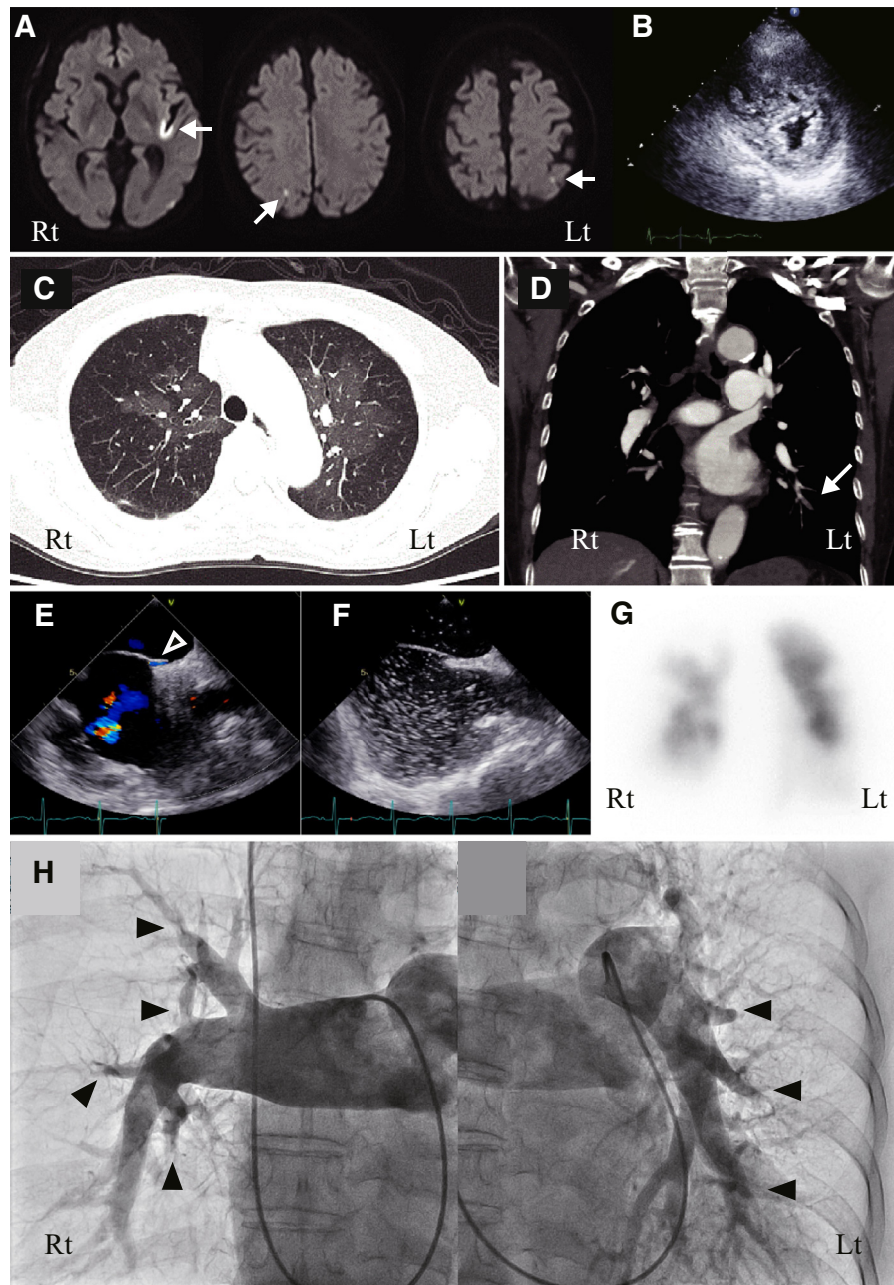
(A) Axial diffusion-weighted magnetic resonance image on admission showing sporadic acute cerebral infarctions in the left insular cortex and bilateral parietal cortices (arrows). (B) Short-axis transthoracic echocardiogram on admission showing a D-shaped left ventricle due to compression by a markedly dilated right ventricle. (C) Contrast-enhanced computed tomography (CT) scan showing a mosaic perfusion pattern, patchy areas of decreased attenuation intermingled with areas of increased attenuation in bilateral lung fields. (D) Coronal CT pulmonary angiogram showing mural thrombi in the left peripheral pulmonary arteries (arrow). (E) Color Doppler transesophageal echocardiography (TEE) showing color-flow communication (open arrowhead) through a patent foramen ovale (PFO). (F) Contrast-enhanced TEE showing translocation of microbubbles from the right atrium to the left atrium after a Valsalva maneuver, indicating a right-to-left shunt through a PFO. (G) Anterior ventilation/perfusion scan showing unmatched perfusion defects in bilateral lung fields. (H) Pulmonary angiogram showing intimal irregularities and abrupt narrowing of the right pulmonary arteries in addition to pouch defects in the left pulmonary arteries (closed arrowhead), consistent with chronic thromboembolic pulmonary hypertension.
